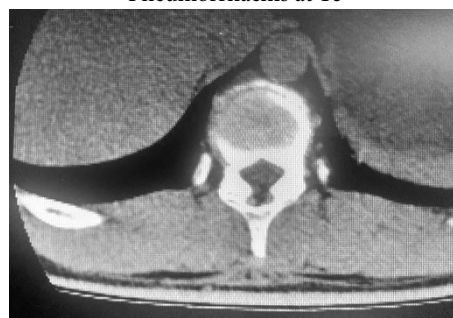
Lumbar spine CT scan showing Pneumorrhachis at the height of L3
